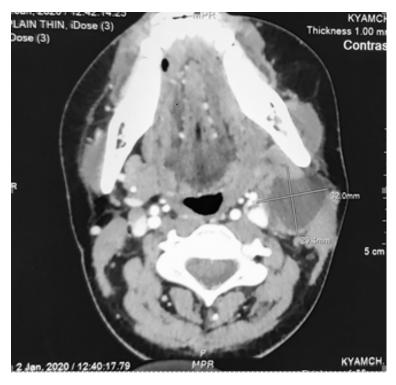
Contrast CT scan of neck showing metastatic left level II lymph node with cystic change infiltrating adjacent sternocleidomastoid muscle
